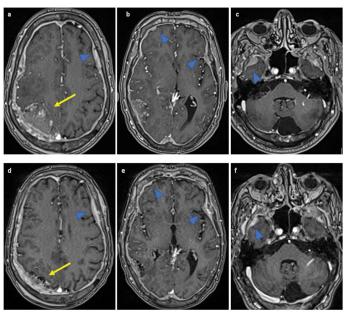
Regression of the right parieto-occipital extra-axial lesion (yellow arrow) and meningeal thickening (arrowheads) in the post-radiotherapy MRI (d-f) as compared to initial MRI (a-c).
